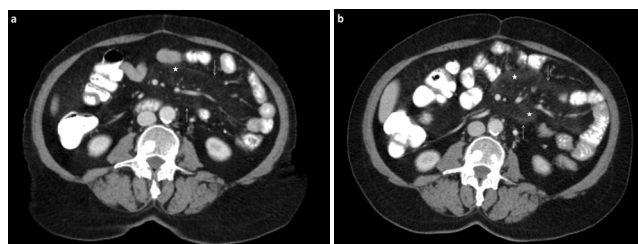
A 67-year old female patient with breast cancer. Baseline CT (a) and follow-up CT (b) scans demonstrate increased MP findings. Density of mesenteric fat (asterisk) and size of MP increased. Borders of pseudocapsule are more prominent (arrows) when compared with previous CT scan.
